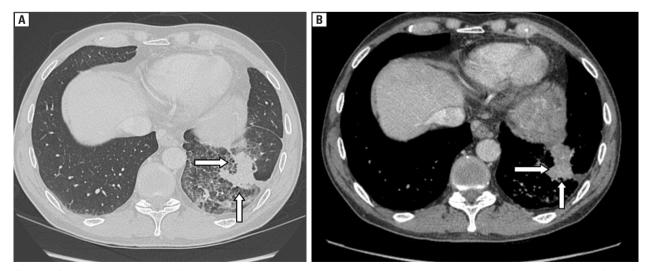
Computed tomography axial images demonstrate a heterogenous consolidation and ground glass opacities in the lower lobe of the left lung: A. Lung window (the lesion — white arrows); B. Soft-tissue window (the lesion — white arrows)
